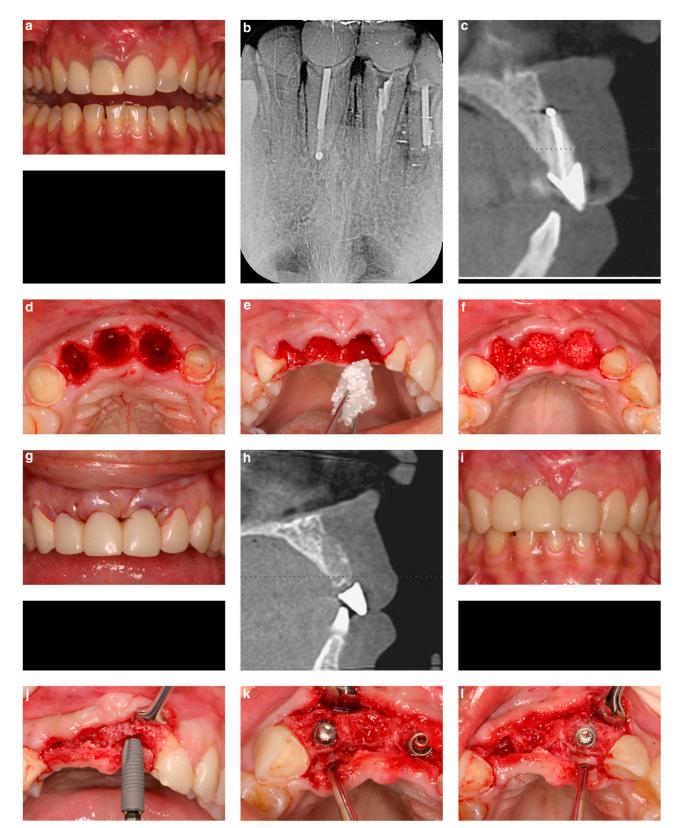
Case 1. 1a Preoperative view of failing maxillary anterior teeth (#7 through #9). The patient had chronic fistulas over the apical mucosa. 1b A periapical radiograph of the failed maxillary incisors. 1c A cross-sectional view of a maxillary CT scan revealed no facial bone over the roots. 1d The maxillary extraction sockets with a lack of a facial cortex. 1e The rhBMP-2/ACS mixed with bone substitute was placed into the sockets. 1f The graft mixture was packed level with the palatal bone margins. 1g A provisional bridge was used as temporary tooth replacement during healing. 1h A cross-sectional view of a CT scan after 5 months of graft healing. 1i A preoperative view before implant surgery. 1j Placement of two implants (Osseospeed TX, Astra Tech) in the reconstructed maxilla. 1k An occlusal view of the left lateral incisor implant. Note the regeneration of the facial cortex. 1l An occlusal view of the right central incisor implant. Note the regeneration of the facial cortex. 1l An occlusal view of the right central incisor implant. Note the regeneration of the facial cortex. 1l An occlusal view of the right central incisor implant. Note the regeneration of the facial cortex. 1l An occlusal view of the right central incisor implant. Note the regeneration of the facial cortex. 1l An occlusal view of the right central incisor implant. Note
